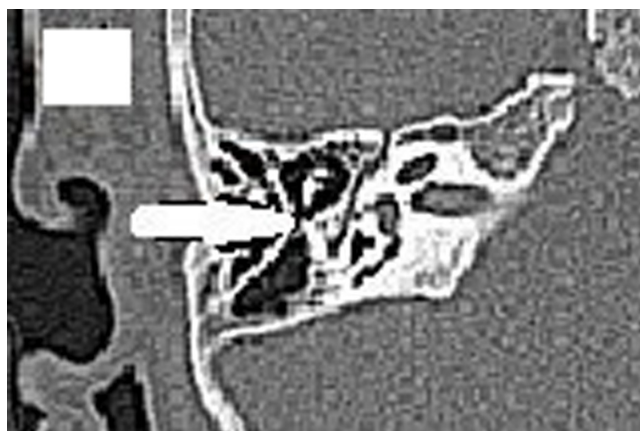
An axial cut of the right temporal bone HRCT, showing Koerner septum (it was scored 1 mark). HRCT, high-resolution CT scan.
